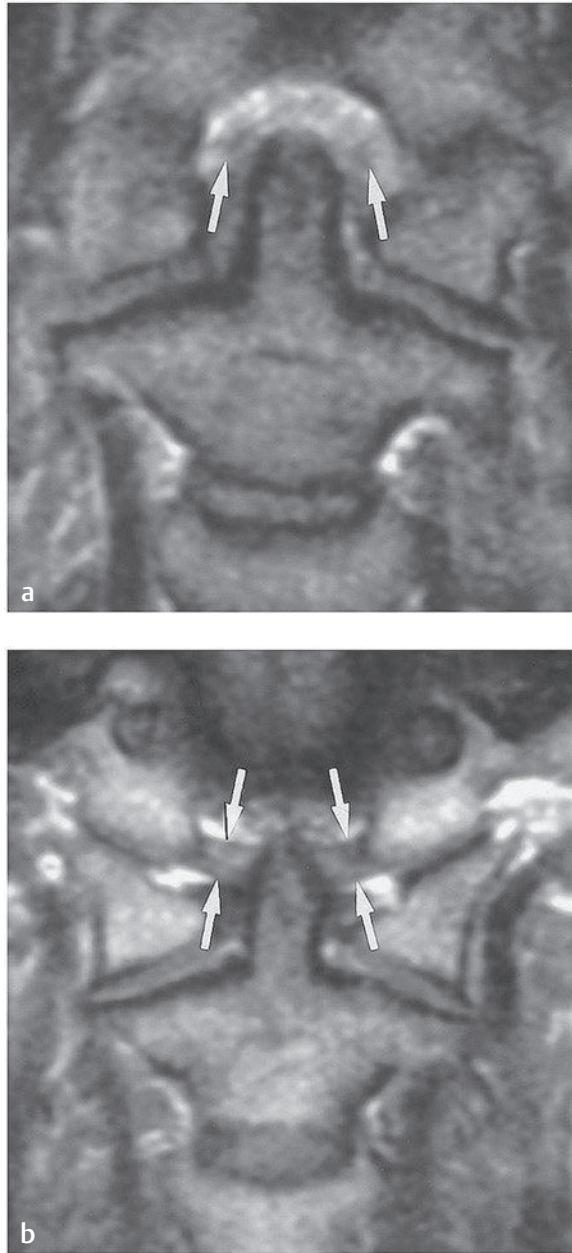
The intact alar ligaments (*arrows*) in a normal spine are very difficult to identify on (a) a coronal T2-weighted image but are more easily visualized on (b) a specialized intermediate-weighted image.
